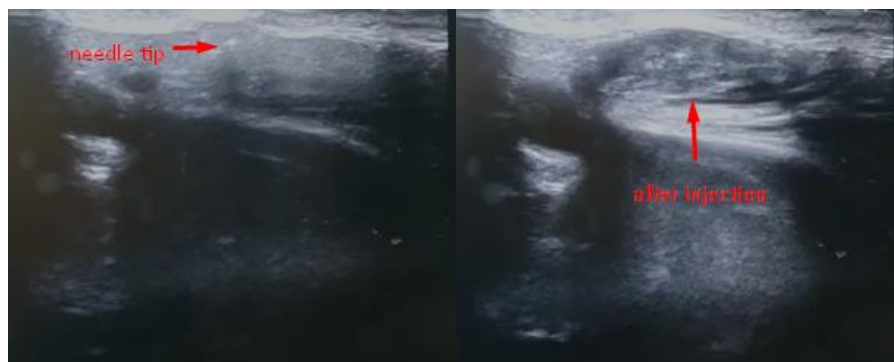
Ultrasound-guided injection before and after injection of botulinum at the parotid gland (case 6)
